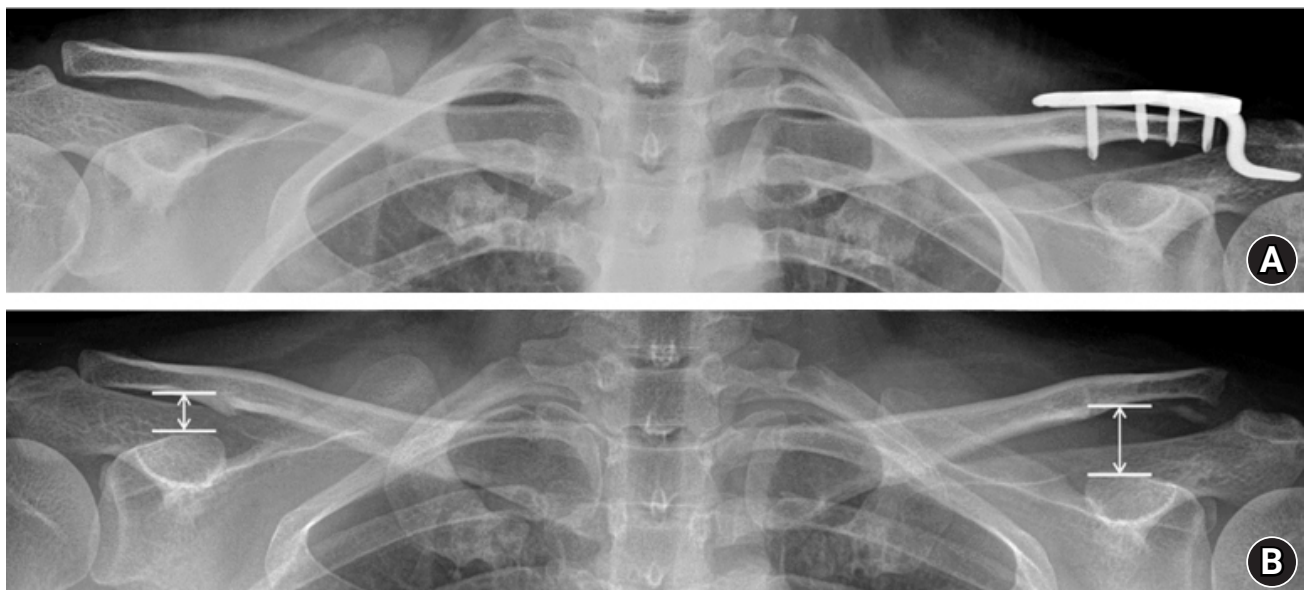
Anteroposterior radiograph of a patient treated with hook plate fixation for an acromioclavicular joint injury. (A) Hook plate fixation with intentional over reduction. (B) Six months after implant removal. The coracoclavicular distance was defined as the perpendicular distance from the highest point of the coracoid cortex to the lower margin of the clavicle cortex.
